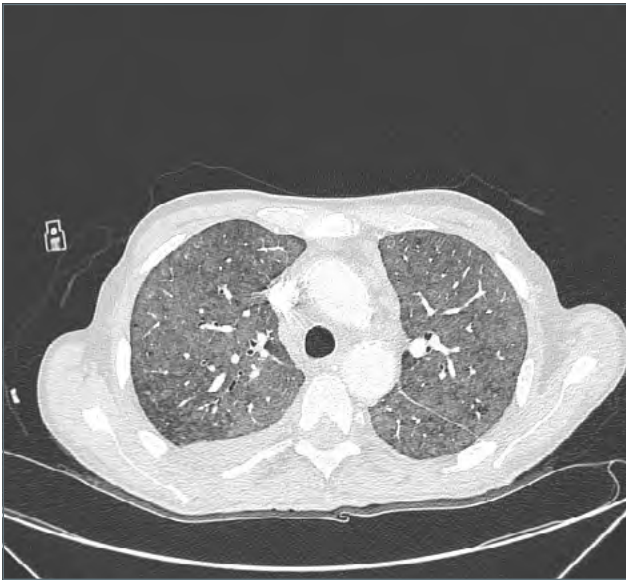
Computed tomography scan of the patient showing ground glass areas with an inflammatory aspect involving almost all-lung parenchyma.
